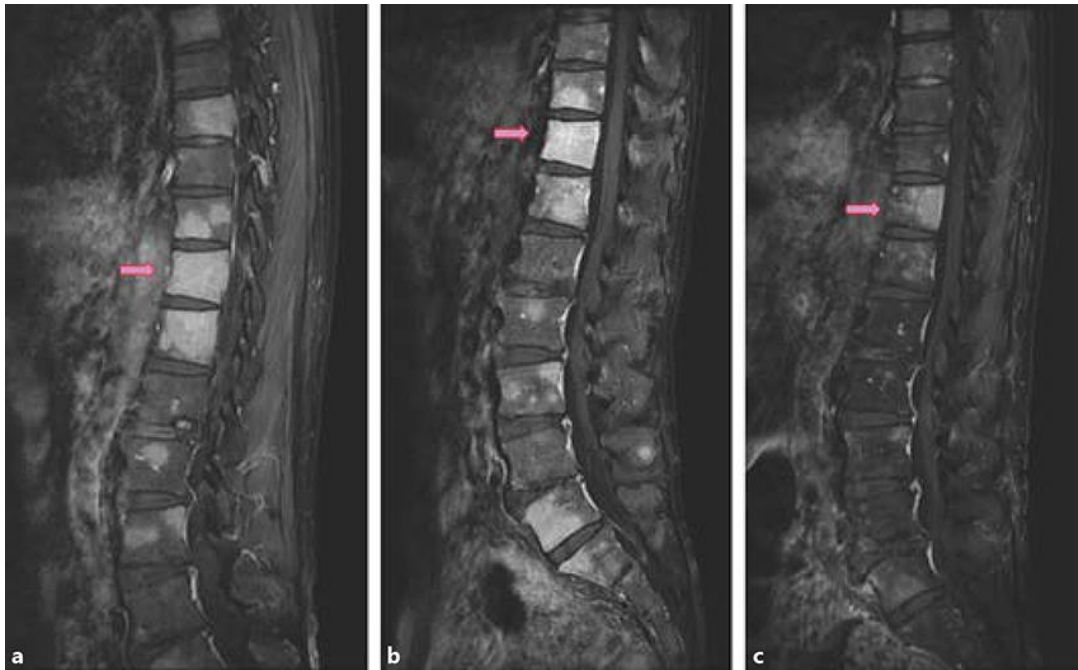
Magnetic resonance imaging at initial diagnosis (a), at after 6 cycles of modified THP-COP (cyclophosphamide 1,200 mg [90%], pirarubicin 80 mg [90%], prednisolone 60 mg day 1–5) treatment (b), and at 9 months after the initiation of pralatrexate treatment (c). Asterisks indicate Th 11.
